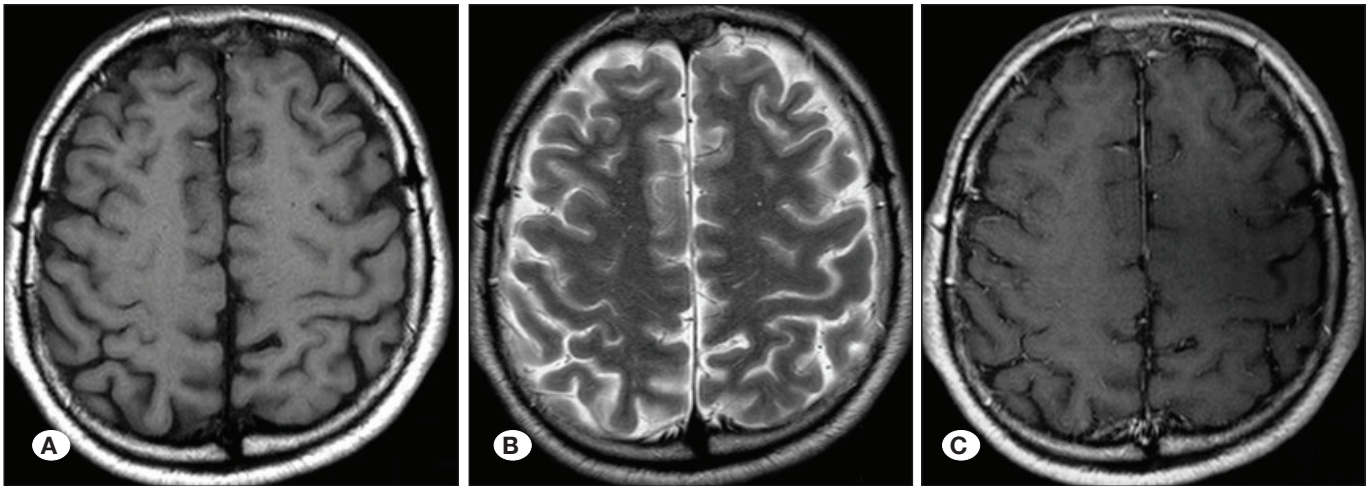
Postoperative Cranial MRI. A) T1W axial, B) T2W axial, C) T1W axial+with contrast.
